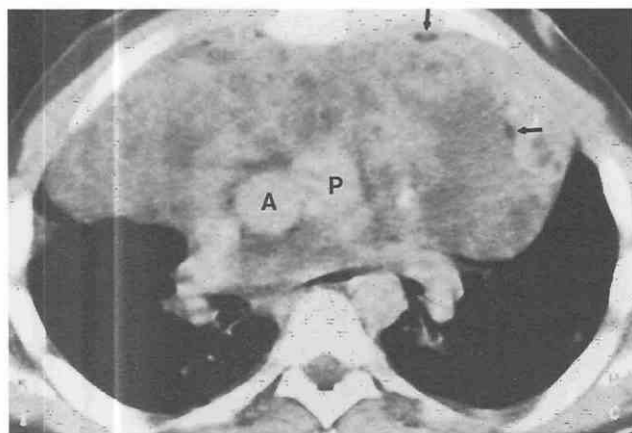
Malignant teratoma. Contrast-enhanced CT shows a large anterior mediastinal mass. The mass is heterogeneous in attenuation with components of soft tissue, fluid, calcium, and fat (arrows). The mediastinal invasion is diffuse. A, aorta; P, pulmonary artery.
